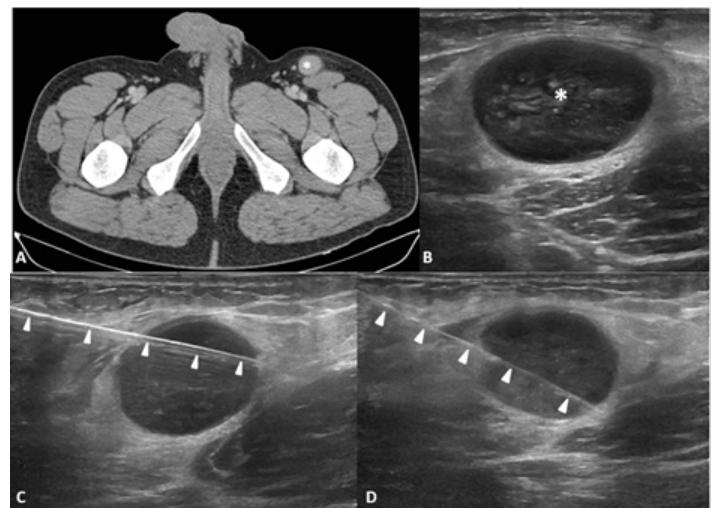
Pelvic computed tomography (A) and ultrasonography (B) showing lymph node enlargement in the left inguinal region (white asterisk). Large needle core biopsy (white arrowheads), with samples being obtained from different areas (C and D).
